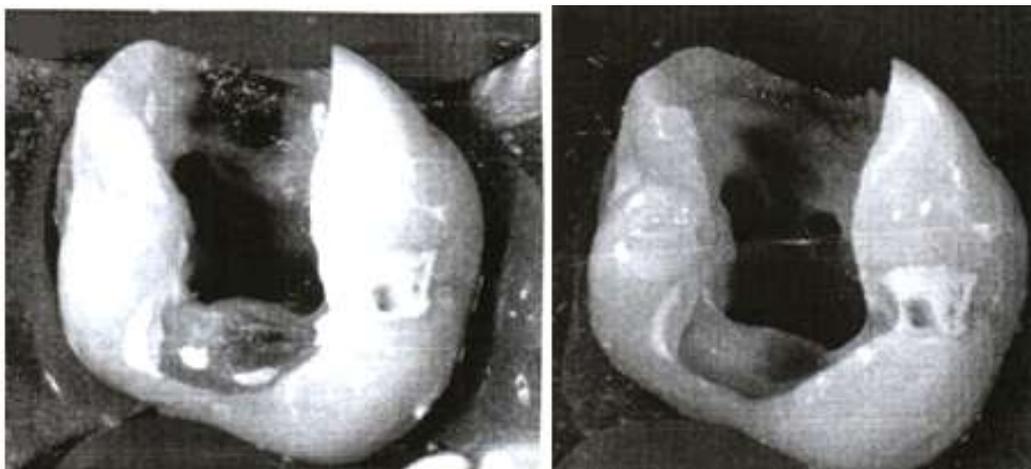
Finding the access at the orifice of the root canal mesiovestibulary MV2 into a superior molar: a – performing the access by classic methods; b – performing the access with endodontic intruments ultrasounds activated
